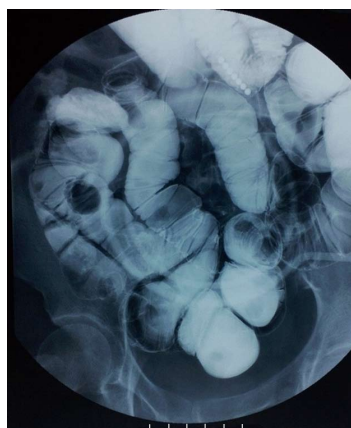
Small intestinal double contrast radiography revealed multiple submucosal masses in the small intestine.
